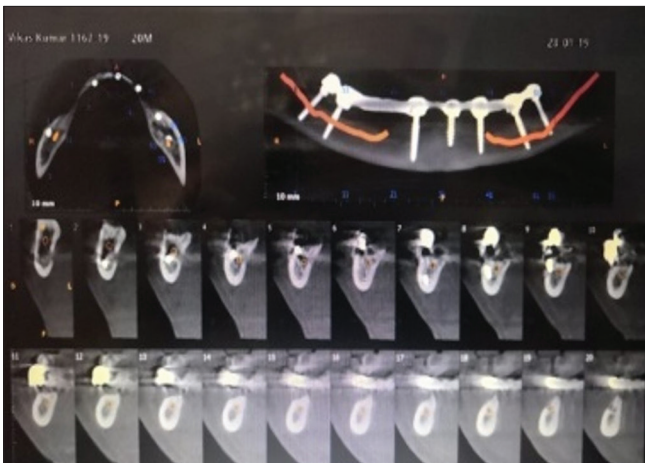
Postoperative CBCT showing implant placement after nerve bypass
